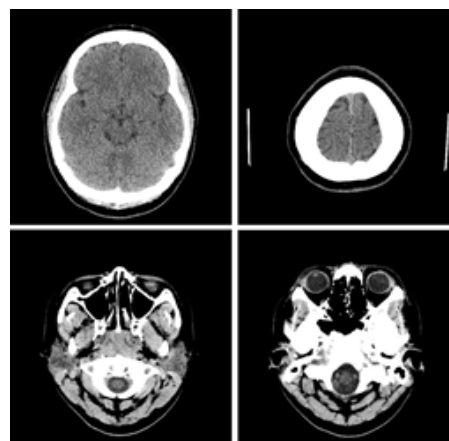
Axial computed tomography scan sections of the skull obtained using the multi slice technique without intravenous iodinated contrast.
